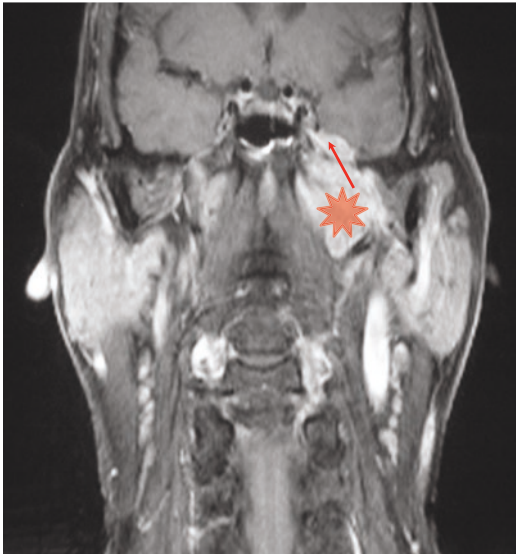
Coronal T1W fat-sat post-Gd MRI. This image demonstrates a tumour (*adenoid cystic carcinoma) in the left masticator space extending along the mandibular division of CN V into Meckel's cave to involve the trigeminal ganglion
